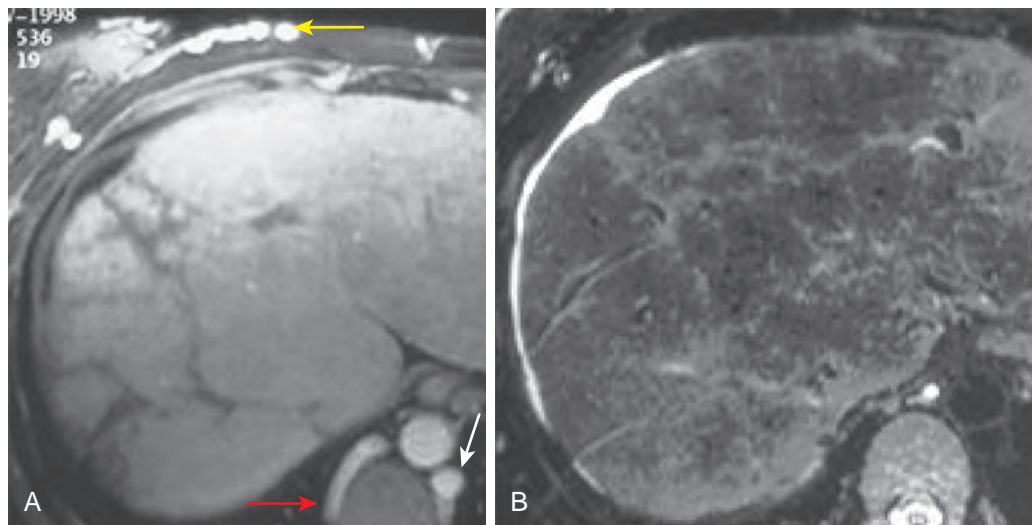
Chronic Budd-Chiari syndrome: MRI findings. A. Postgadolinium image shows no demonstrable inferior vena cava or hepatic veins. Note the dilated azygos vein (red arrow), hemiazygos vein (white arrow), and superficial collateral (yellow arrow) blood vessels. B. T2-weighted image shows inhomogeneous, coarsened hepatic parenchyma. Ascites is present.
